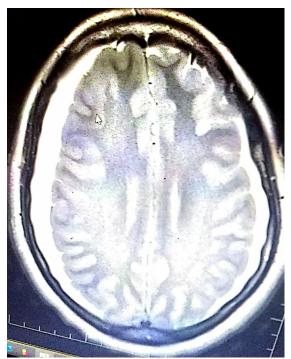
Magnetic resonance imaging (MRI) of the brain showing bilateral subdural hematoma
